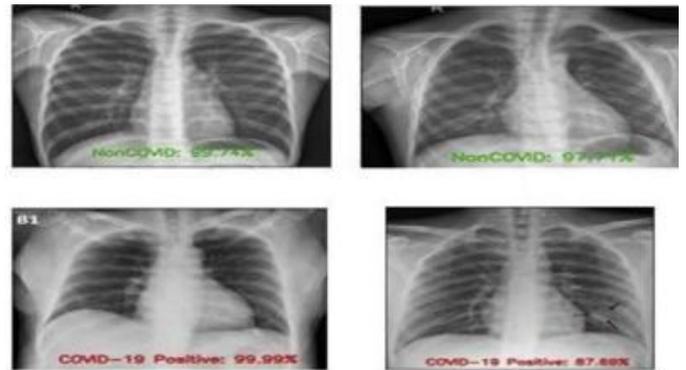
a. The various sample X-ray images shown above demonstrate that the model identifies the images as whether covid or non-covid.
